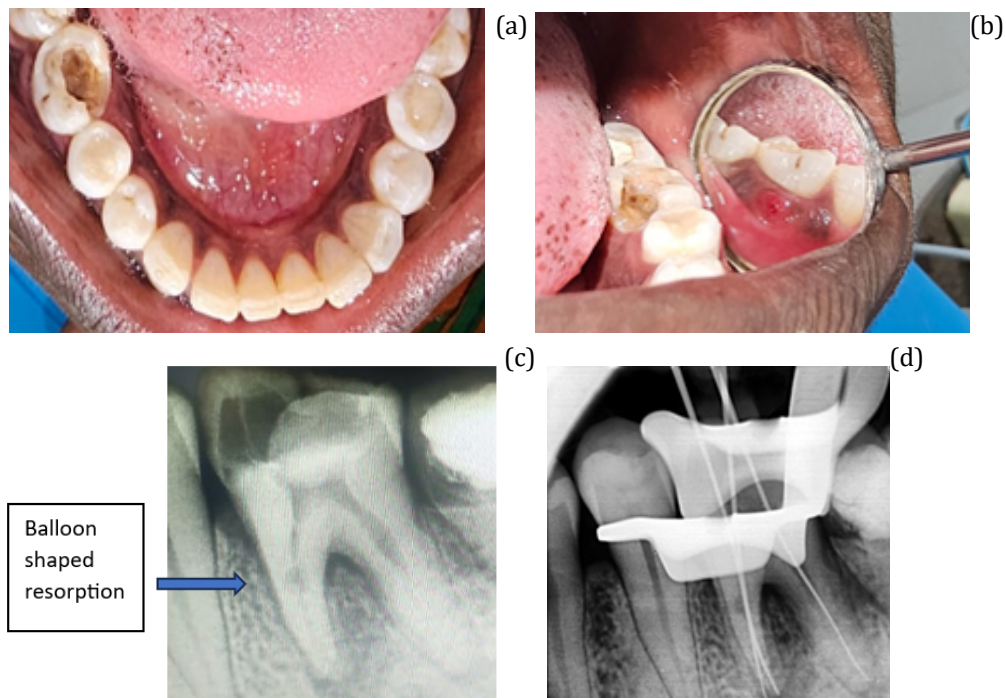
(a): Intraoral clinical photograph (Occlusal View); (b): Sinus opening seen on buccal aspect i.r.t 36; (c): Intraoral periapical (IOPA) radiograph i.r.t 36; (d): Working length determination.
